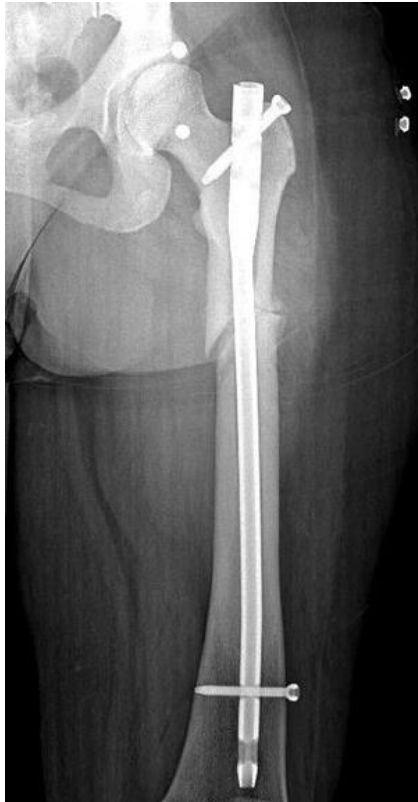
Postoperative anteroposterior x-ray of the left hip. The protruding proximal end of the nail is demonstrated.
